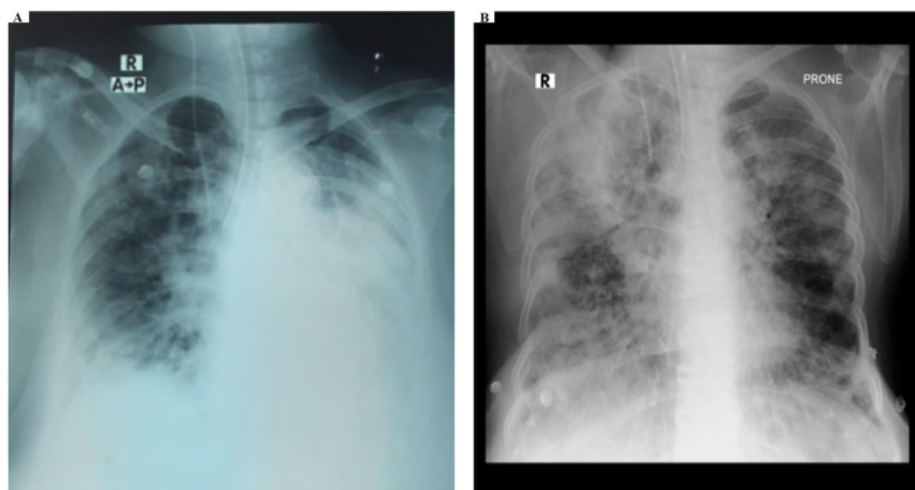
X-ray examination results on the third participant.
